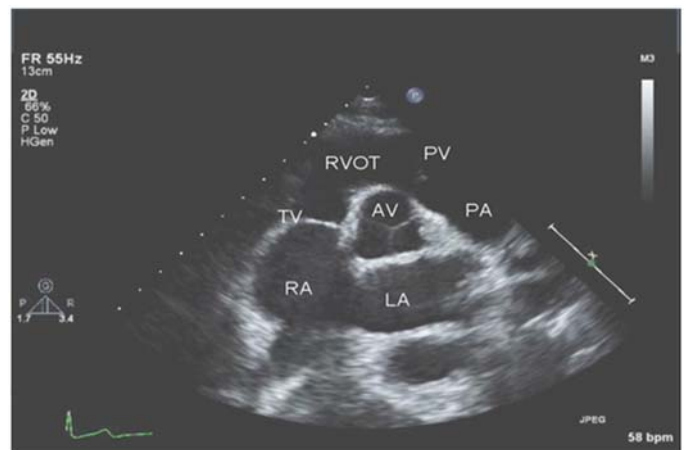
Parasternal short axis (PSAX)
